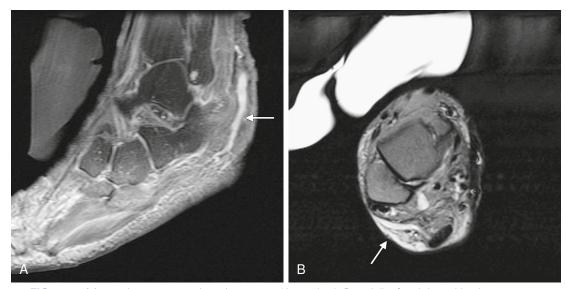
Magnetic resonance imaging scans (A, sagittal; B, axial) of a right ankle demonstrate tenosynovitis involving the posterior tibialis muscle following a strain injury *(arrows)*. (From The Ohio State University Wexner Medical Center, Columbus, Ohio.)
